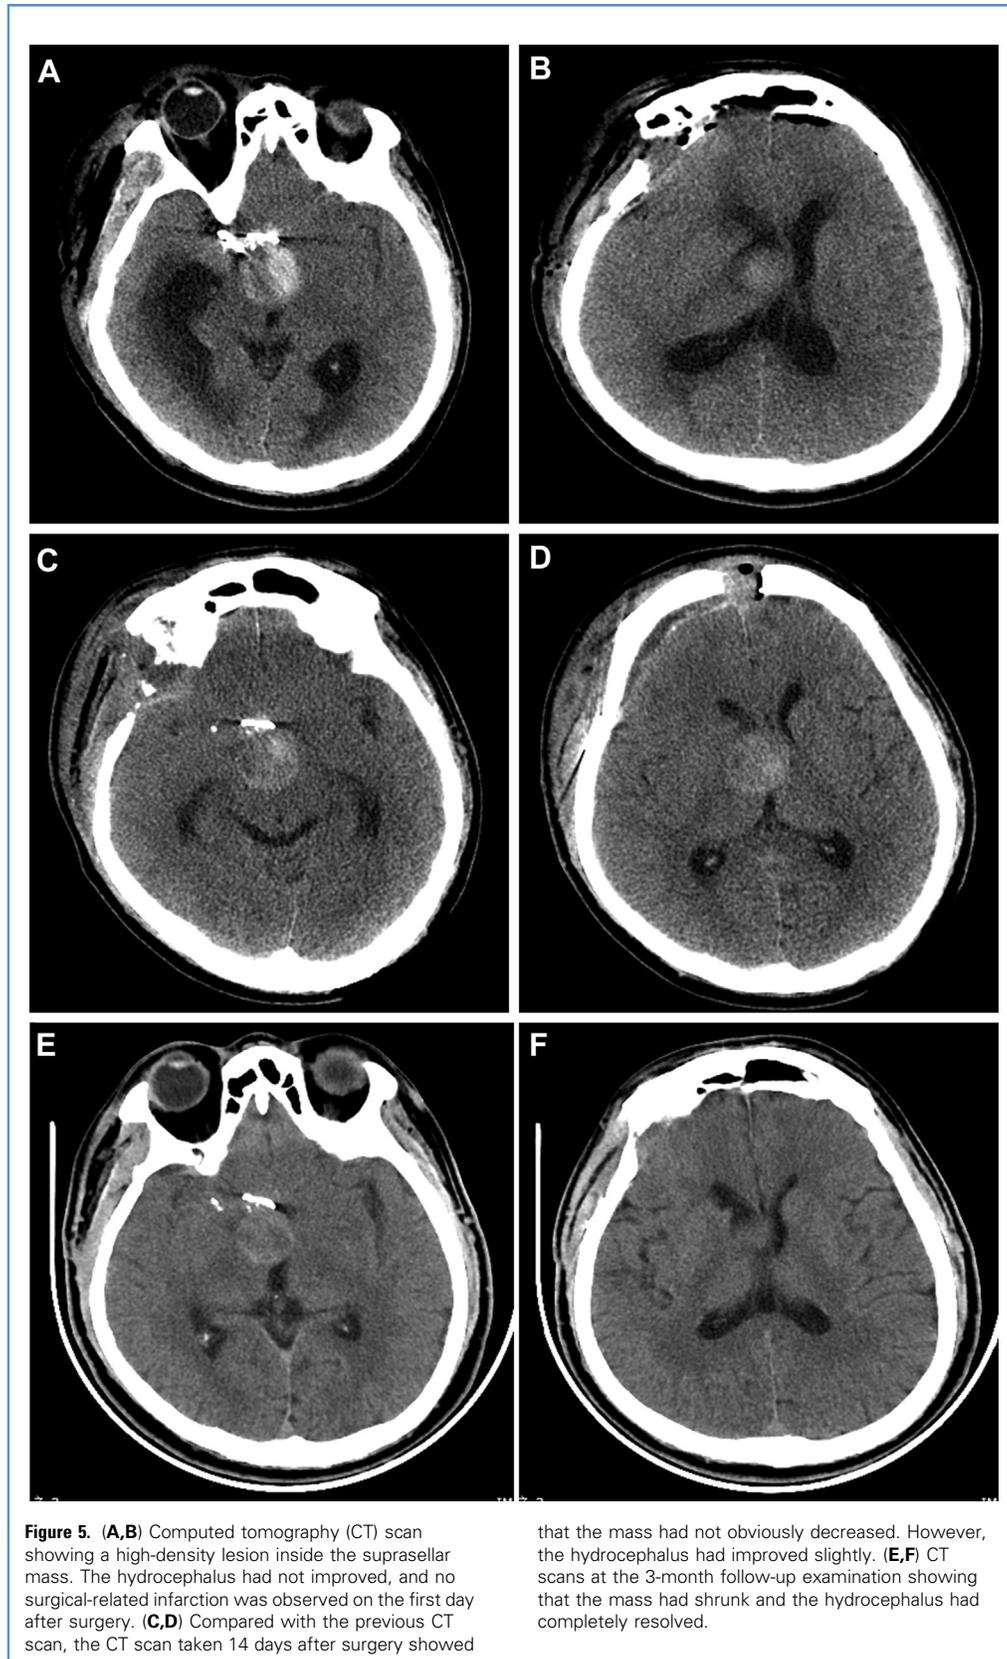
(A,B) Computed tomography (CT) scan showing a high-density lesion inside the suprasellar mass. The hydrocephalus had not improved, and no surgical-related infarction was observed on the first day after surgery. (C,D) Compared with the previous CT scan, the CT scan taken 14 days after surgery showed
